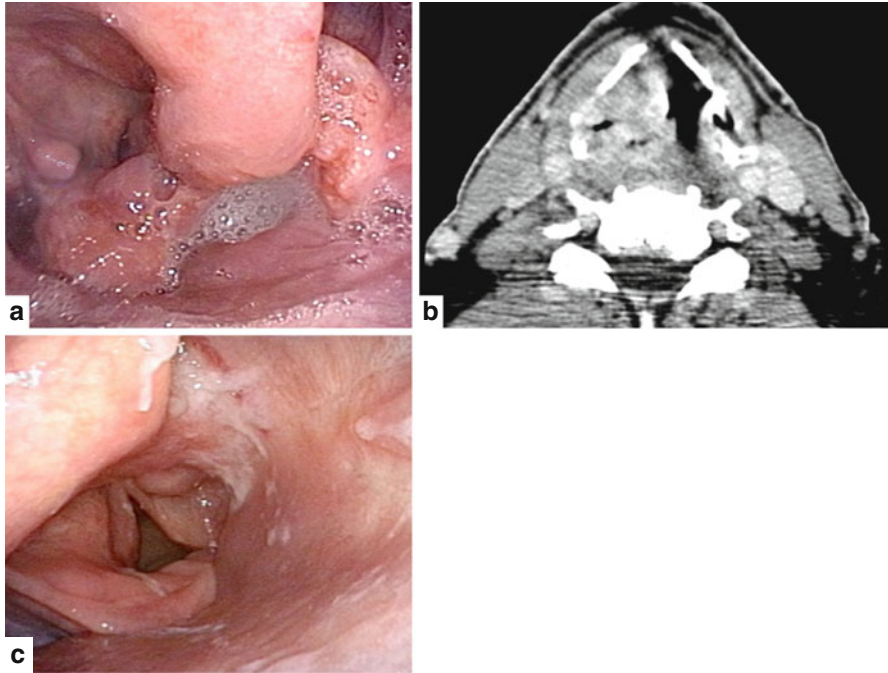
(a) Endoscopic view of a T4a hypopharyngeal SCC of the right pyriform sinus and supra-glottis. (b) Preoperative CT scan showing infiltration of the thyroid cartilage and adjacent tissues. (c) Endoscopic view 4 years after TLM and adjuvant CRT
